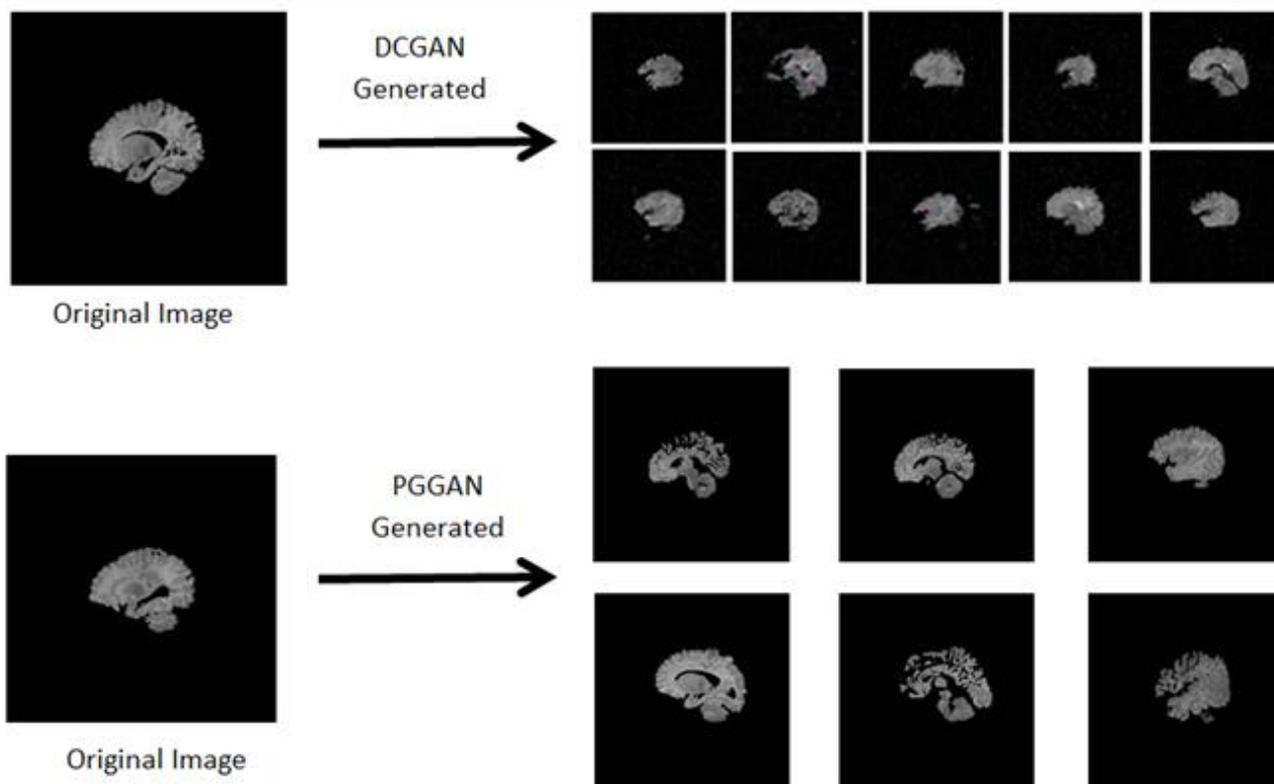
Our synthetic brain generation results shows that DCGAN can generate brain images with low image resolution and quality while our proposed image generation method PGGAN can generate high resolution synthetic images from original MRI images.
